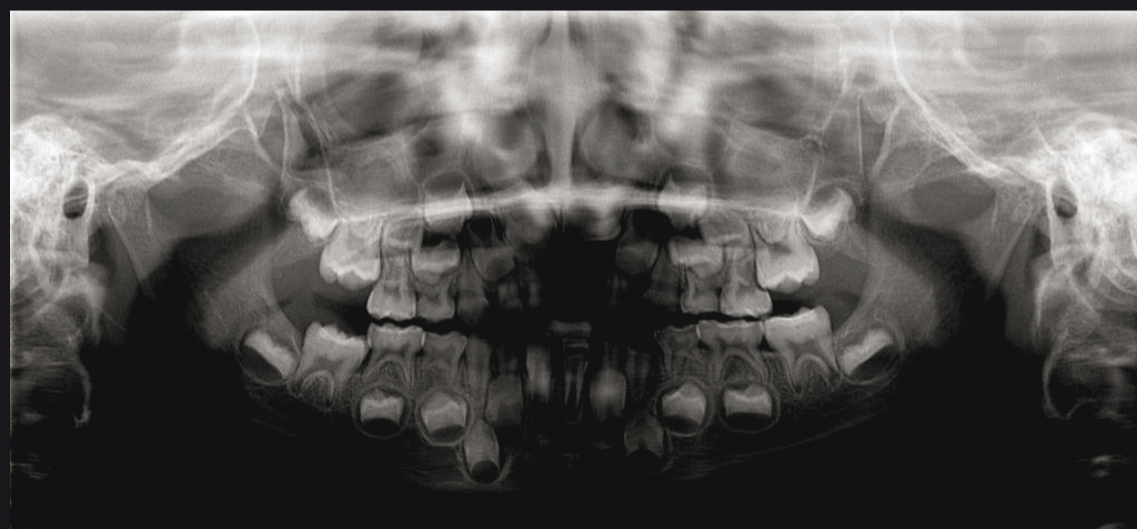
Radiography panoramic
